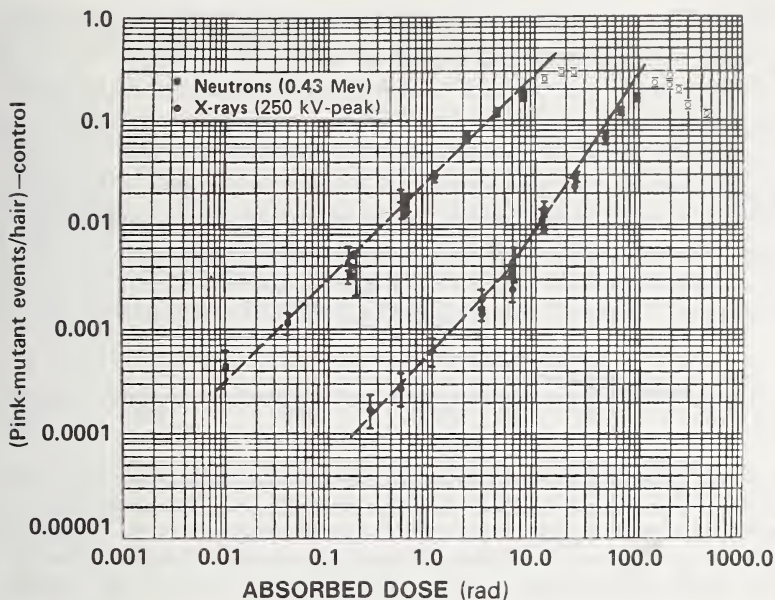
Neutron and x-ray dose-response curves for pink-mutant events in stamen hairs of *Tradescantia* clone 02. The points represent average values obtained by dividing the total number of mutant events by the total number of stamen hairs scored from day 11 through day 15 after irradiation, when the mutation frequency is highest. The open symbols are saturation points and were not used in computing the true slopes. The dashed lines represent slopes based on computations (From Sparrow *et al.*, 1972).
